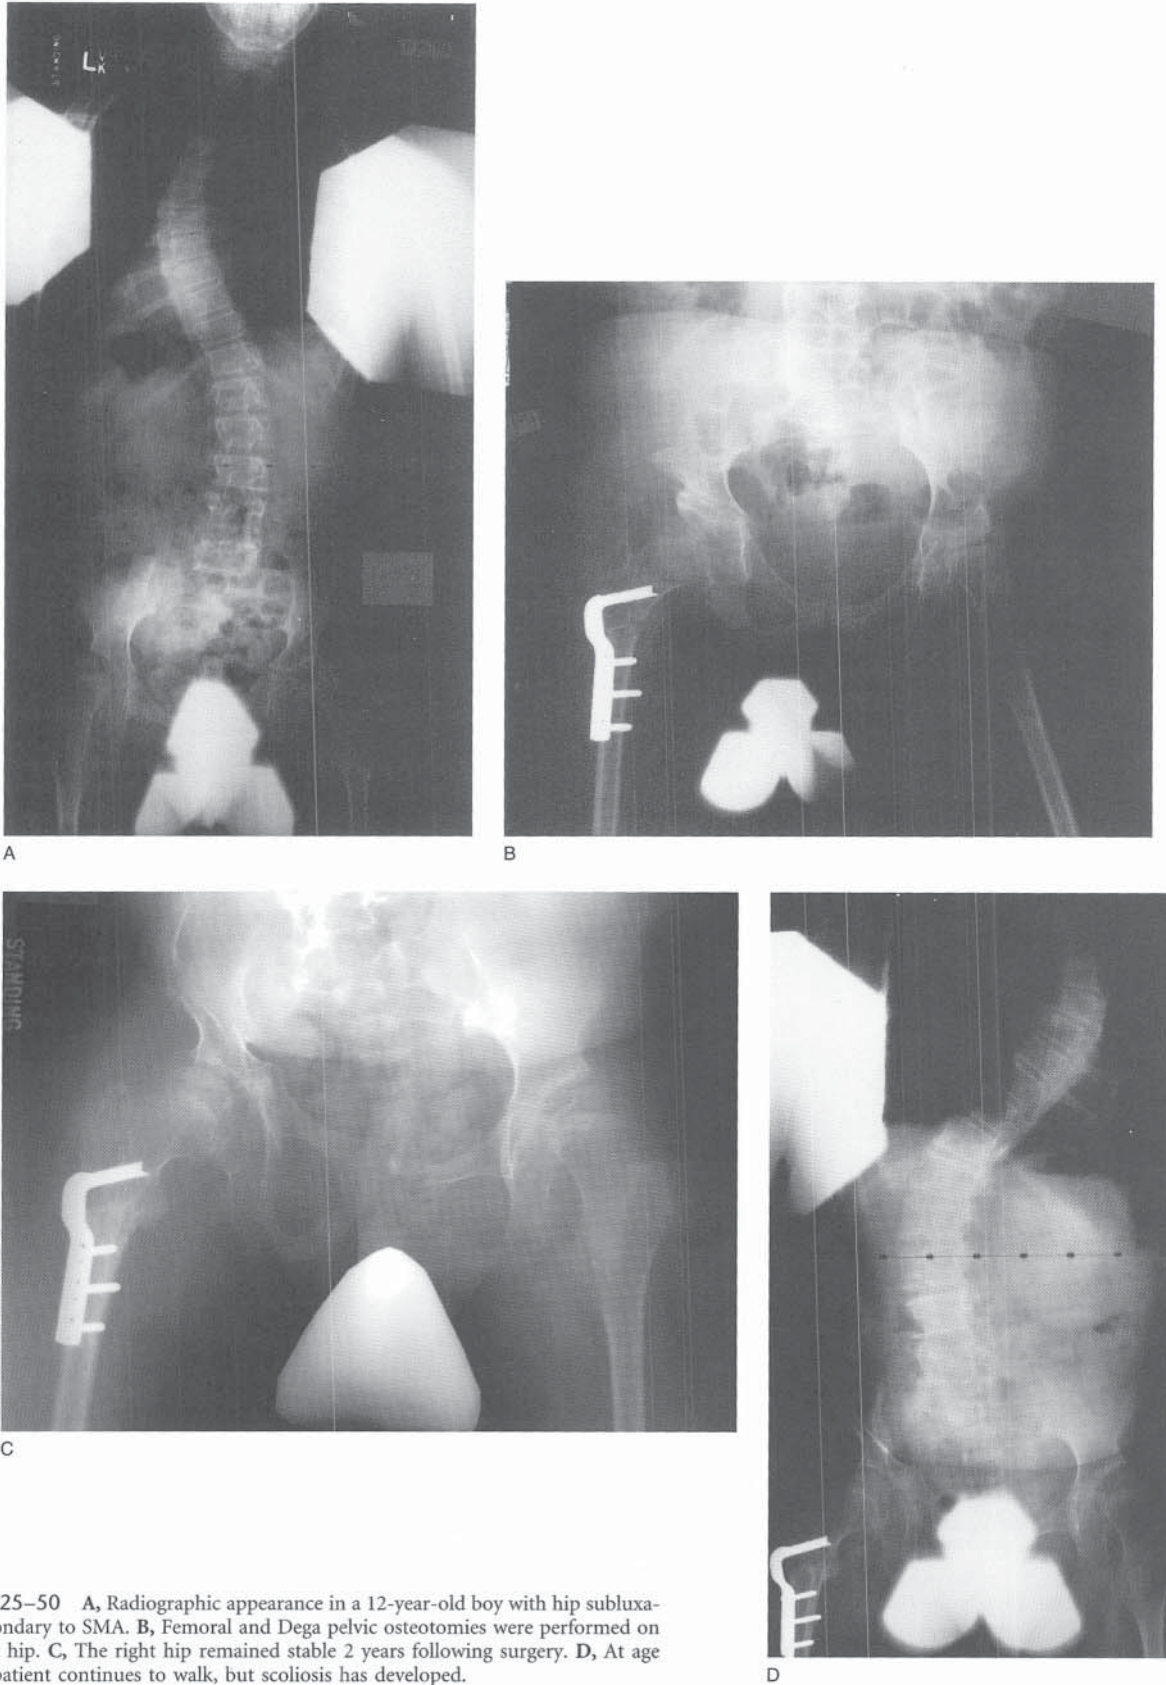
A, Radiographic appearance in a 12-year-old boy with hip subluxation secondary to SMA. B, Femoral and Dega pelvic osteotomies were performed on the right hip. C, The right hip remained stable 2 years following surgery. D, At age 14, the patient continues to walk, but scoliosis has developed.
